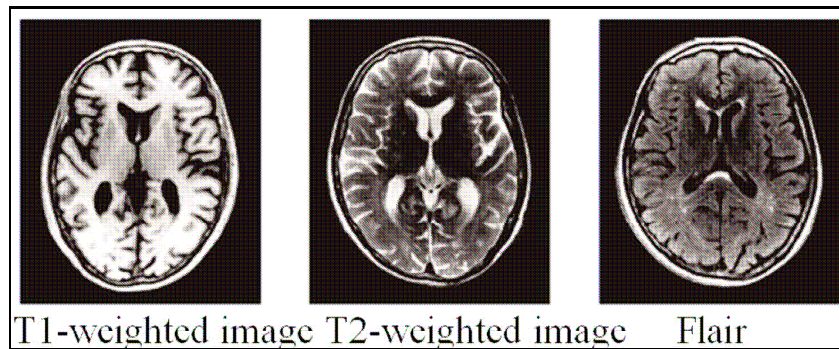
Basic Magnetic Resonance Imaging sequences. Images are taken from one of our participants.
